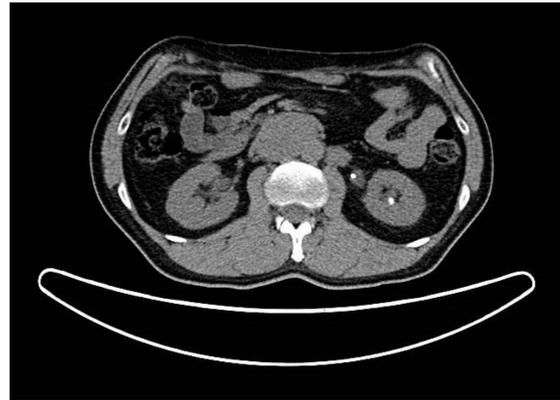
NM Ga68 Dotatate PET/CT abdomen
